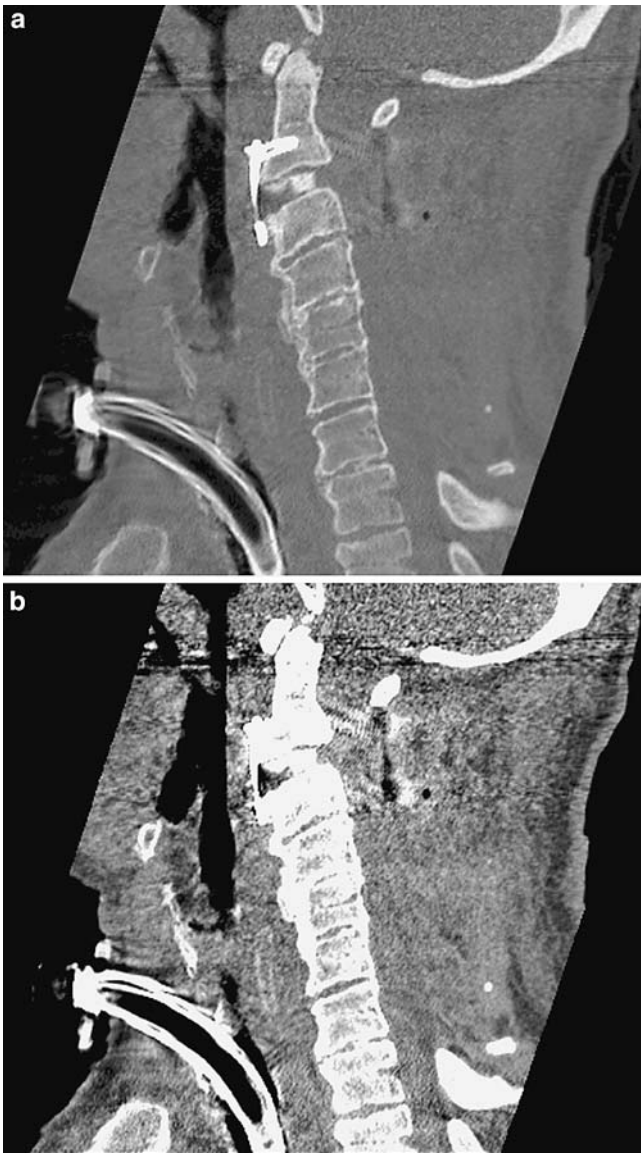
a Post-operative CT (3D reformatted midsagittal image) of the cervical spine demonstrating adequate anatomical alignment at the C2–C3 level. b Post-operative CT (3D reformatted midsagittal image) of the cervical spine demonstrating adequate anatomical alignment at the C2–C3 level
